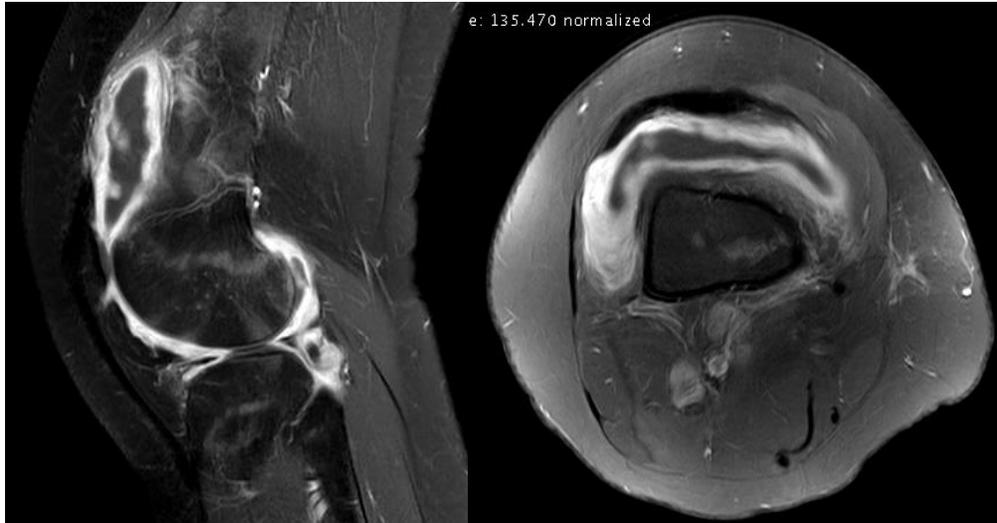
A T2 weighted saggital and axial view MRI of the left knee
